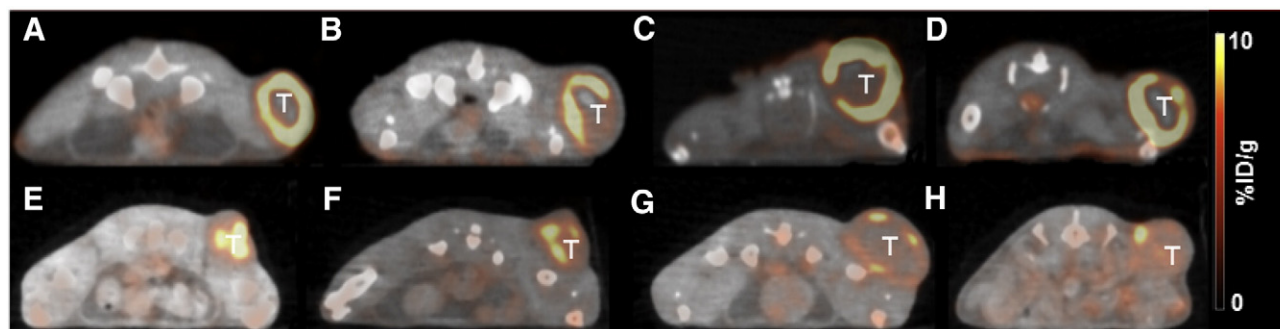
^{64}Cu -liposome PET/CT of FaDu xenografts (top row) (A) non-irradiated control (n = 11), (B) 5 Gy (n = 11), (C) 10 Gy (n = 10), (D) 20Gy (n = 11) and CT26 tumors (bottom row) (E) non-irradiated control (n = 8), (F) 2 Gy (n = 8), (G) 5 Gy (n = 8), (H) 20 Gy (n = 8). (T) Tumor.
